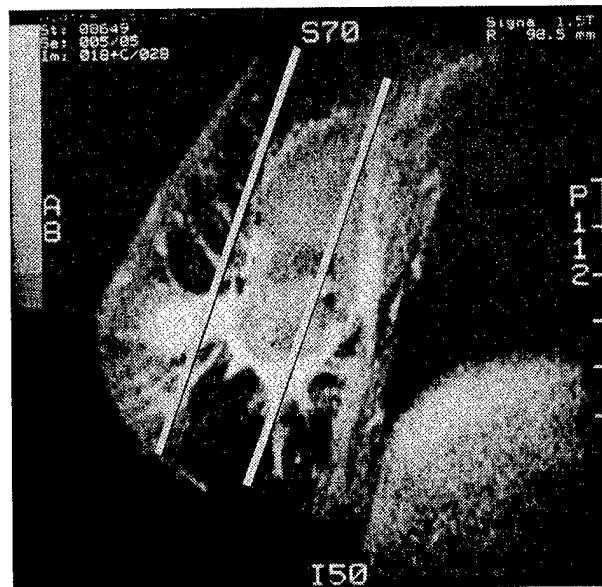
MRI of case 2, who has a large lesion after a lumpectomy. The lesion consists of seroma and fibrous scar tissue.
